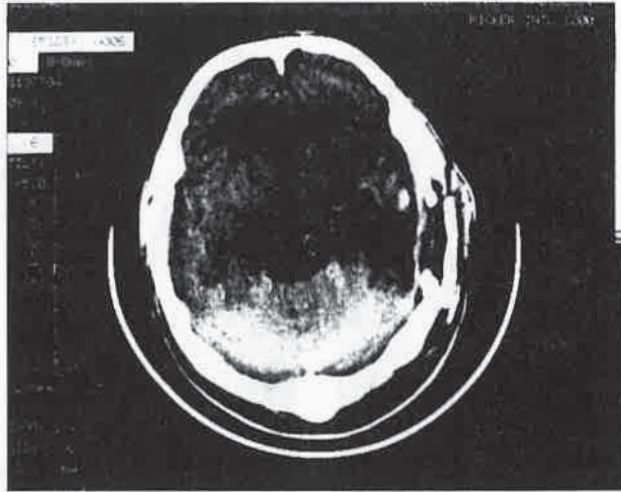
Postoperative axial CT scan demonstrated total excision of the cavernous angioma of the lateral ventricle.
